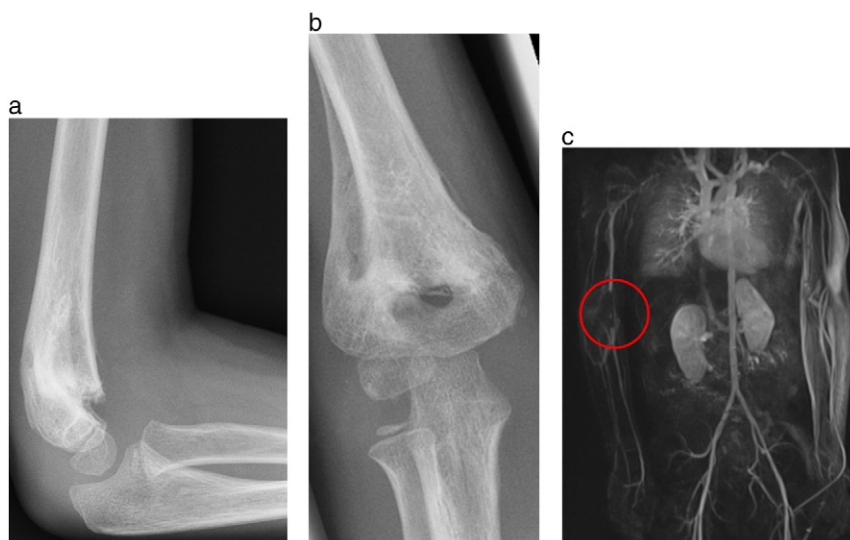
a, b: postoperative X-ray after 2 months and removal of the K-wires; c: closure of the brachial artery in MR-Angiography.
